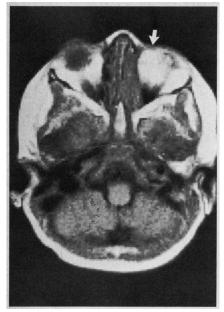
Hyperintense mass (arrow) of left orbit on axial magnetic resonance imaging of T_1 -weighted image.
